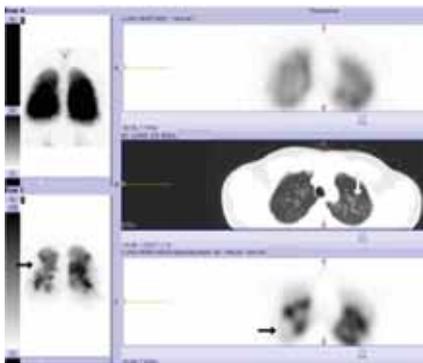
SPECT-VQ/CT in a 50 year old male with CTEPH. There are multiple segmental perfusion defects (black arrows) with normal ventilation. Mosaic attenuation (white arrow) is demonstrated on the low dose CT lung window reconstruction in the mid panel.
